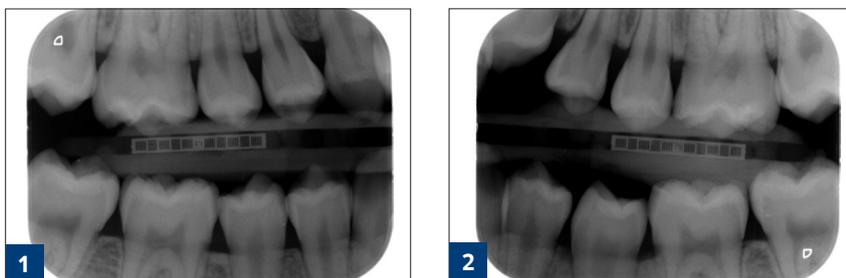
Bitewing radiographs from 1/21/2010
